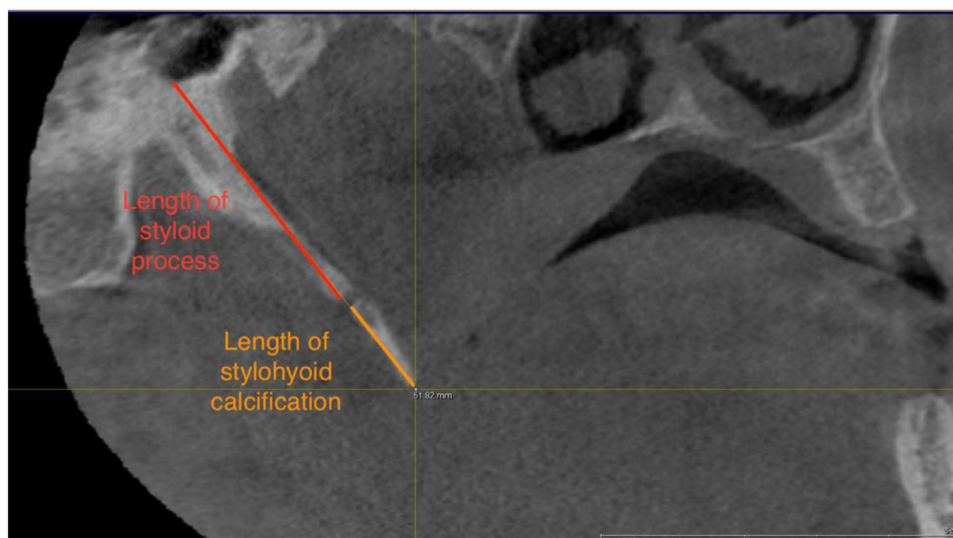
Fig – Cone beam computed tomography image in the sagittal plane showing the length of styloid process and length of stylohyoid ligament calcification.
